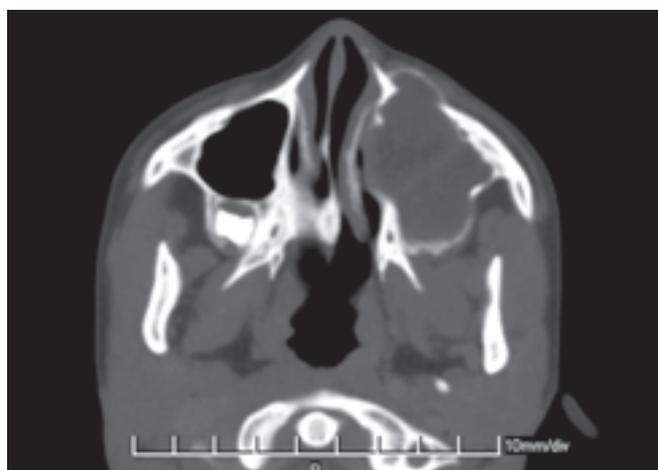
CT scan showing well-demarcated homogeneous cyst in the left maxillary sinus with expansion and thinning of the anterior and posterior walls of the maxilla
